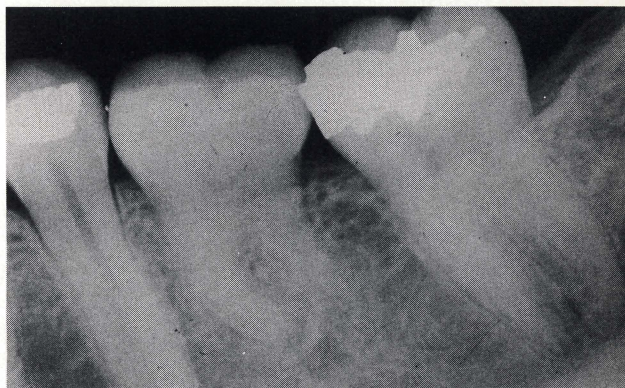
Periapical radiograph, twenty-one months postsurgery.
